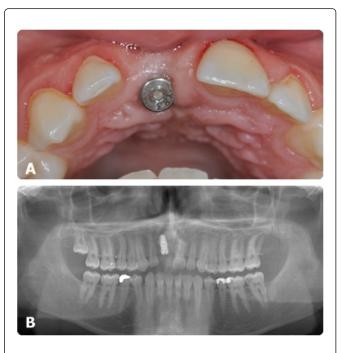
Preoperative examination; A. Intraoral view of the palatinal positioned implant; B. Panoramic radiograph.
